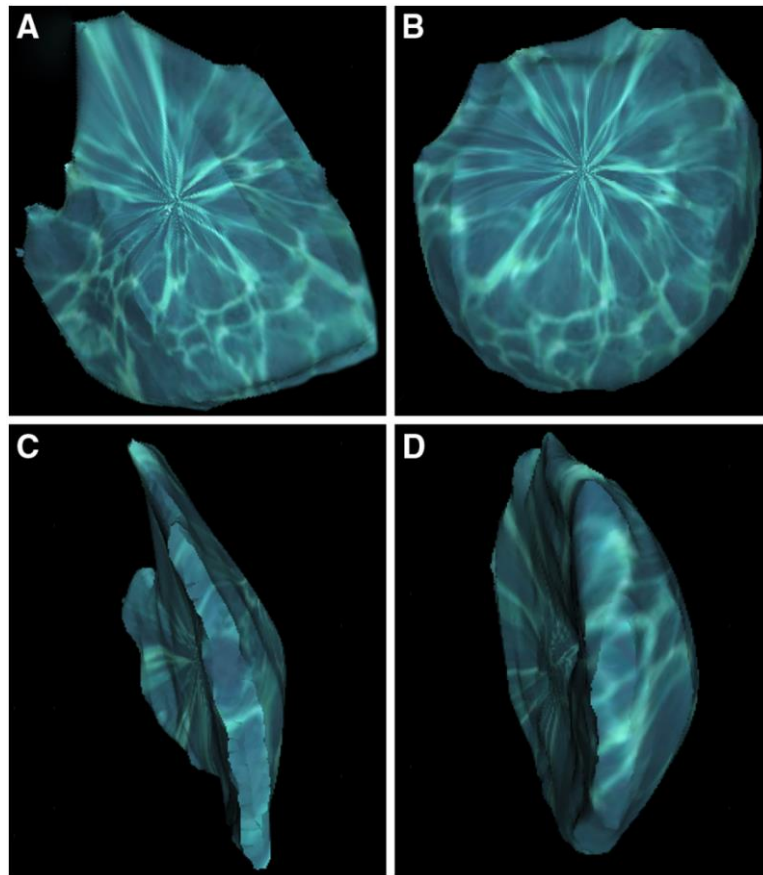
Surface-rendered three-dimensional (3D) reconstruction of a computed tomographic (CT) scan of the breasts, performed with Osirix (Pixmeo, Geneva, Switzerland) software.
